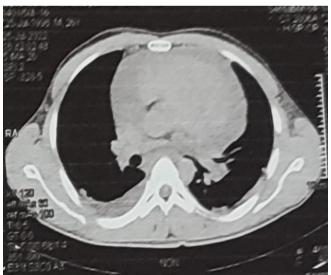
A computed tomography scan showed a mass in the pericardial space located in the anterior mediastinum
